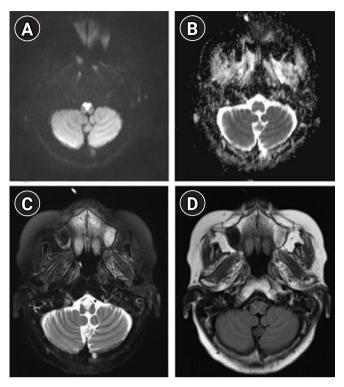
Magnetic resonance imaging (MRI) findings at 2 months of hospitalization after completion of conventional immunotherapy. Follow-up brain MRI revealing expansion of diffusion-restricted lesions on the diffusion-weighted image sequence to both the anteromedial medulla (A) with a subtle signal change on apparent diffusion coefficient sequence (B) and increased perilesional signal intensity on T2-weighted (C) and T2-weighted fluid-attenuated inversion recovery (D) sequences, after completion of immunotherapy including intravenous methylprednisolone and immunoglobulin following completion of four sessions of weekly rituximab treatment.
